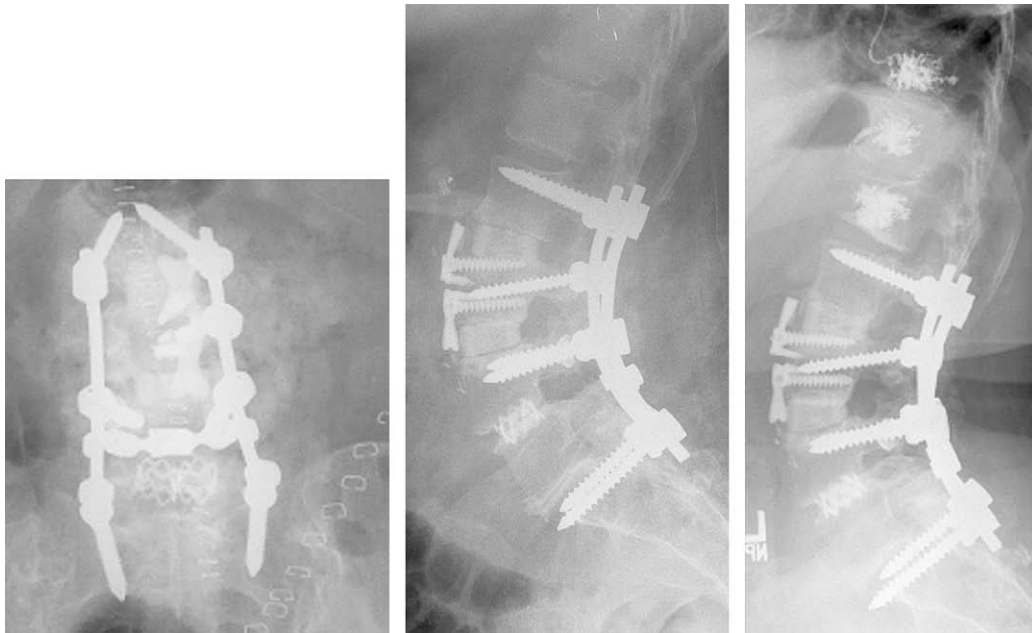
(Left) Antero-Posterior (AP) radiograph prevertebroplasty. Patient underwent L2–L4 fusion because of adjacent segment instability after postlaminectomy spondylosis. (Middle) Lateral radiograph prevertebroplasty. (Right) Lateral radiograph demonstrating L1 compression fracture, which occurred approximately 8 weeks after fusion. This fracture did not significantly collapse and had no effect on the patient's clinical recovery or outcome.
